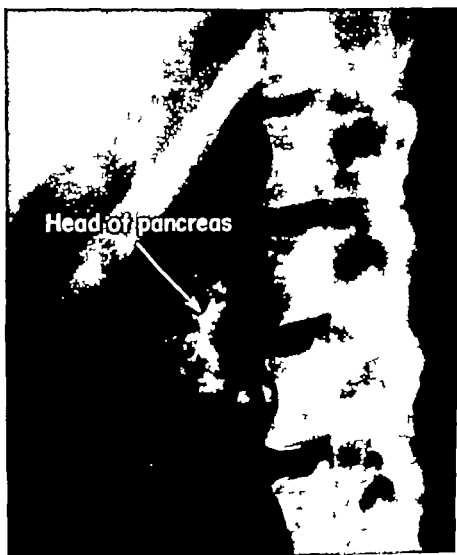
Roentgenogram revealing calcium deposition in the pancreas.
